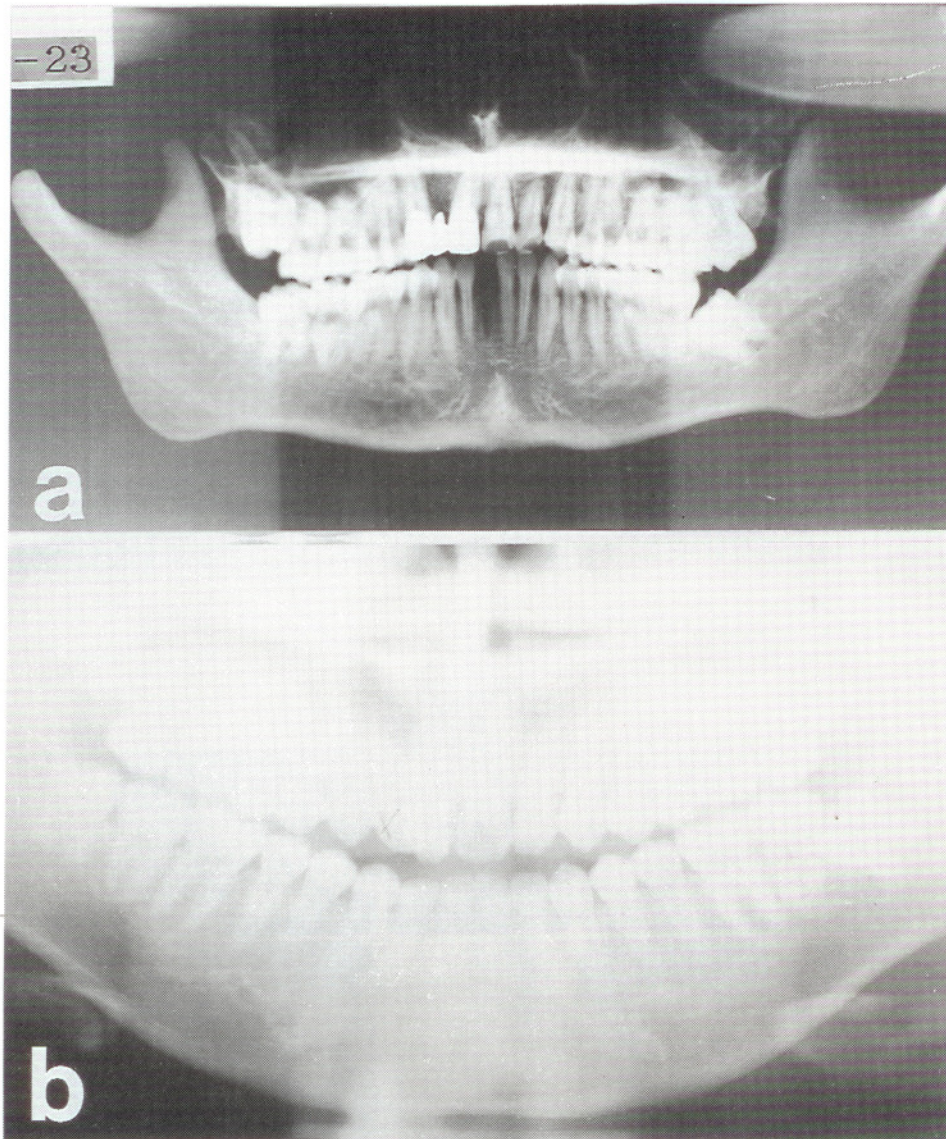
Radiographic comparison of (a) postmortem dental orthopantomograph of Victim E with (b) the antemortem one.
